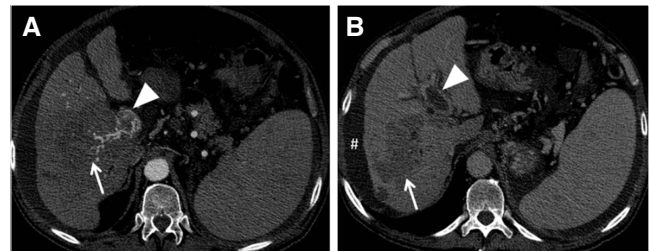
Axial contrast-enhanced computed tomography slices at arterial (A) and portal (B) phases. Note tumor infiltration (arrow) extending from part of the right hepatic lobe to the hilar region and tumor infiltration of the portal vein (arrow head)
